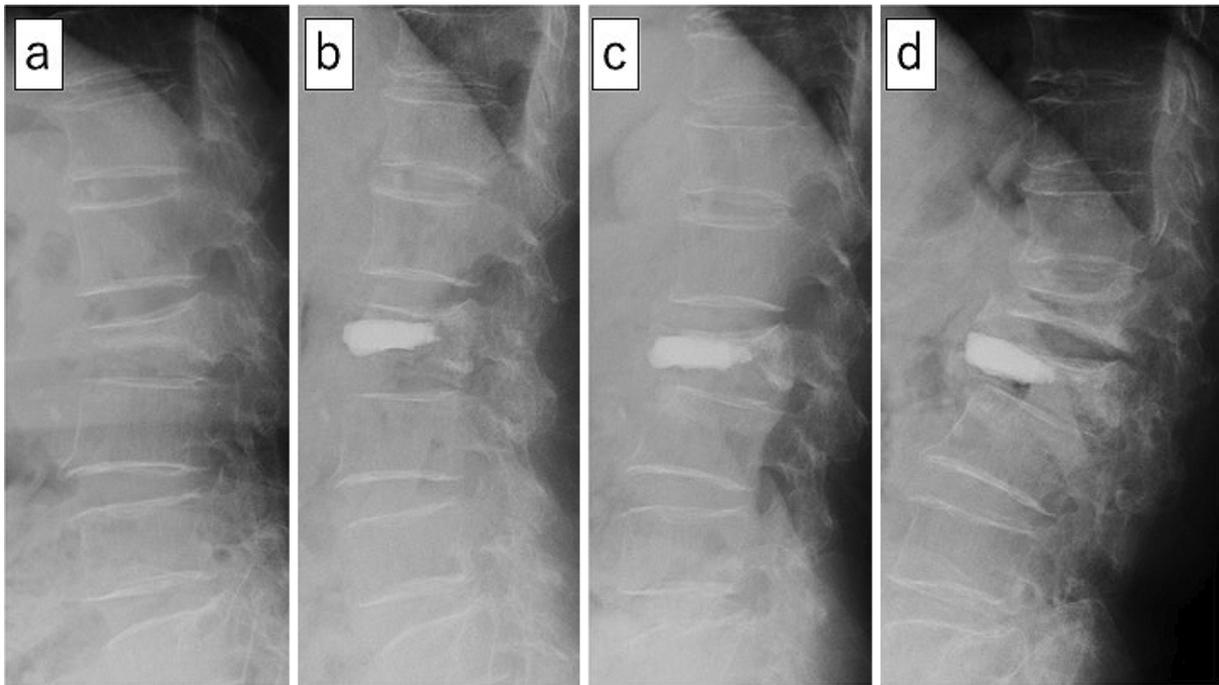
A 78-year-old woman with AVF after augmented vertebral body height loss following BKP. (a) Preoperative radiograph (lateral view) showing the L2 vertebral fracture (vertebral body height=10 mm). (b) Postoperative radiograph (lateral view), 1 week after BKP, showing cancellous bone remaining around the cement in the vertebral body. (c) Postoperative radiograph (lateral view), 1 month after BKP, showing loss of augmented vertebral body height (RAV). (d) Postoperative radiograph (lateral view), 6 months after BKP, showing an adjacent vertebral fracture at L1.
